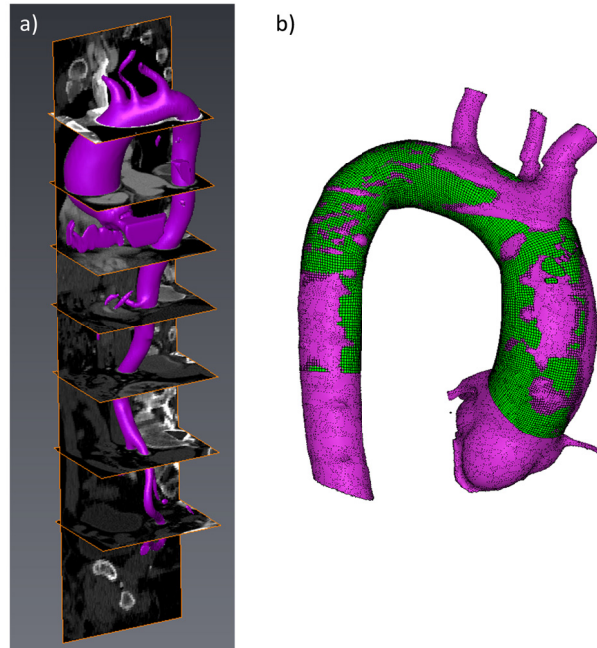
a) Segmented AA surface geometry overlaid with 3D CT data in Avizo software for a representative patient. b) Patient 1 AA FE mesh (green) overlaid with original segmented surface geometry (purple).
